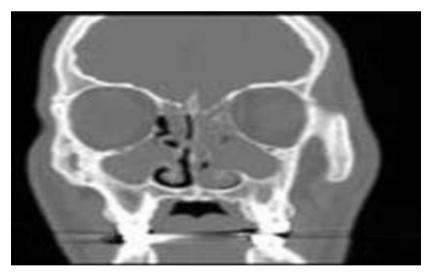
CT nose and paranasal sinuses (PNS) showing isodense, non-enhancing soft tissue swelling in both nasal cavity and right maxillary sinus
